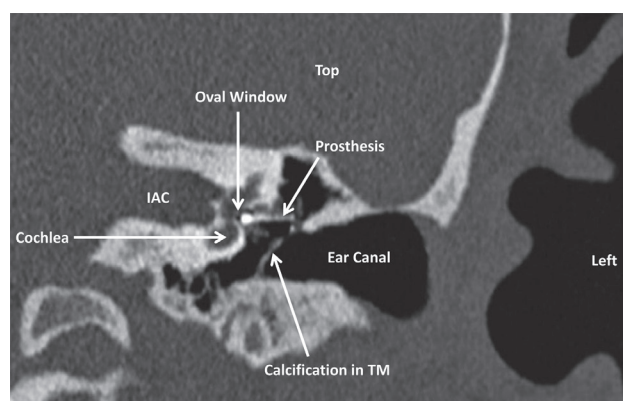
Coronal CT image of the temporal bone showing the separation between the prosthesis and the oval window. Some calcification (white) in the tympanic membrane (TM) seen due to tympanosclerosis.
